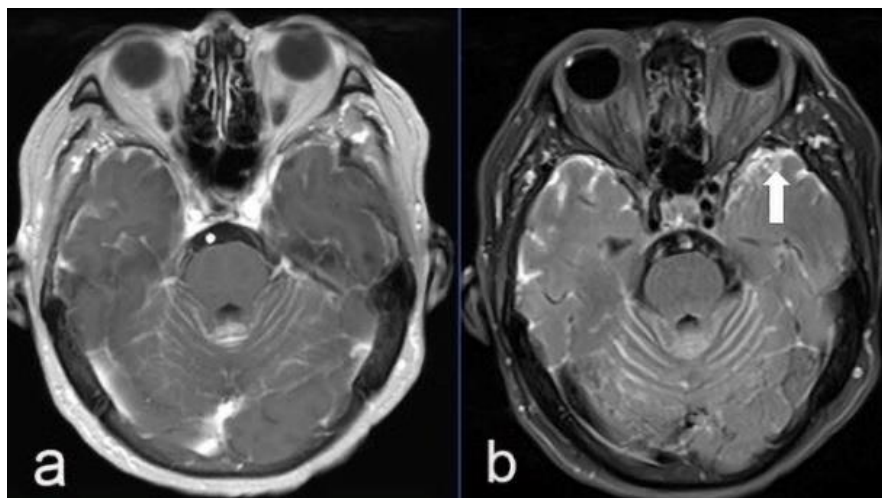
(A) The extension of leptomeningeal metastases on CE FLAIR (arrow, B) was larger than that on CE T1WI.
